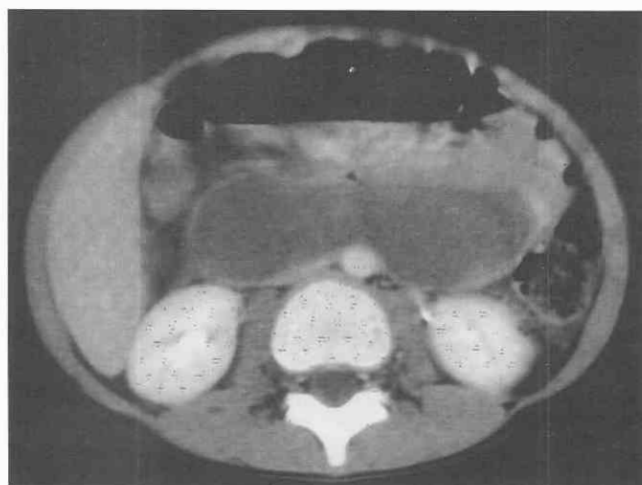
Intramural duodenal hematoma. CT scan through the upper abdomen in a patient following blunt abdominal trauma demonstrates a large, dumbbell-shaped duodenal hematoma.
